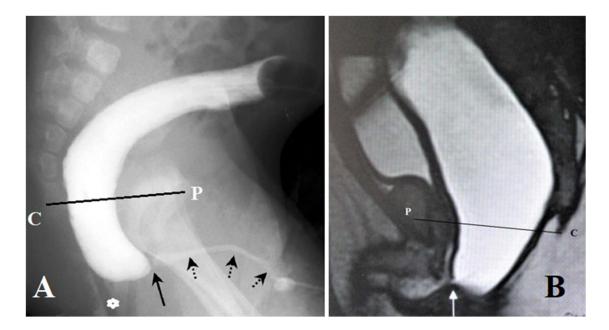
Examples of the X-ray (A) and MRI (B) augmented-pressure distal colostogram. In both cases during high pressure in the rectum, the contrast agent penetrated the wide anal canal. The fistula is in the distal part of the anal canal.
